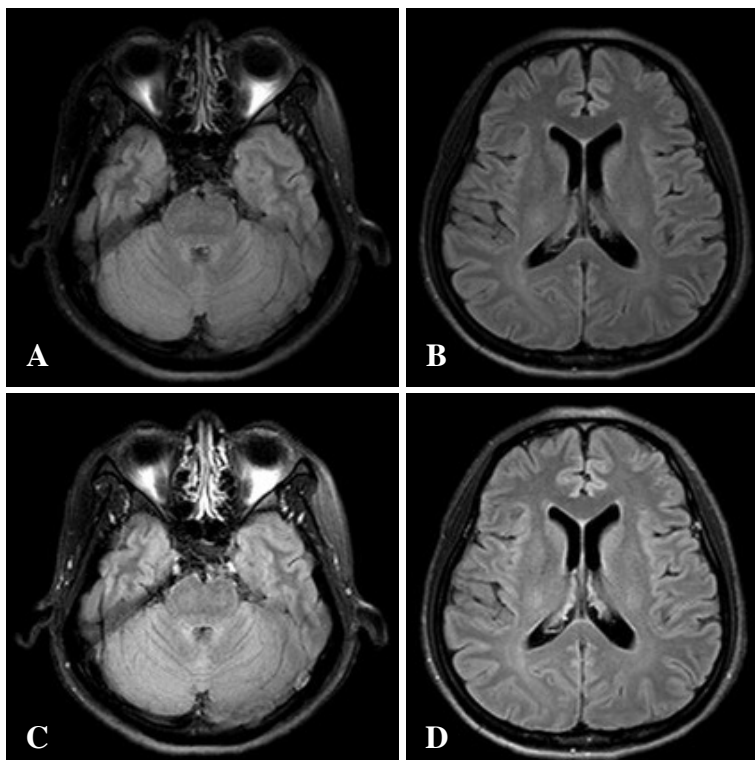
MRI brain T2 flair technique shows normal brain parenchyma (A,B) and post gadolinium injection reveals no enhancement (C,D).
